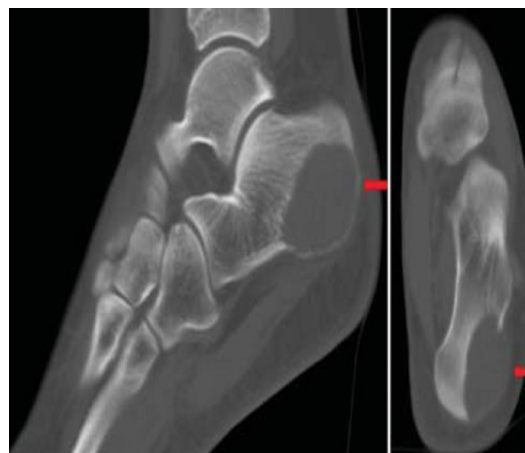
17-year-old female with pain in the left heel diagnosed as due to an aneurysmal bone cyst. CT scans of the left foot (left) sagittal and right ) coronal views show lytic mass lesion (arrow), 35 × 25 mm in dimension, localized postero-laterally, leading to cortical bone erosion, expansion, and destruction [94].
